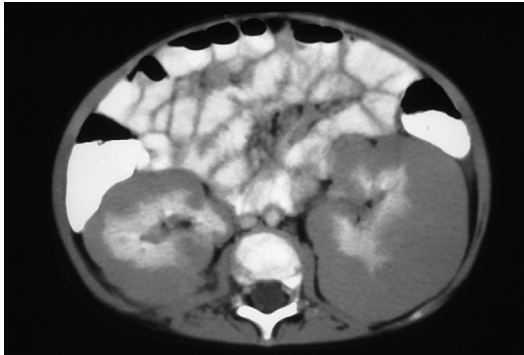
CT scan of the abdomen demonstrating diffuse perilobar hyperplastic nephroblastomatosis.
